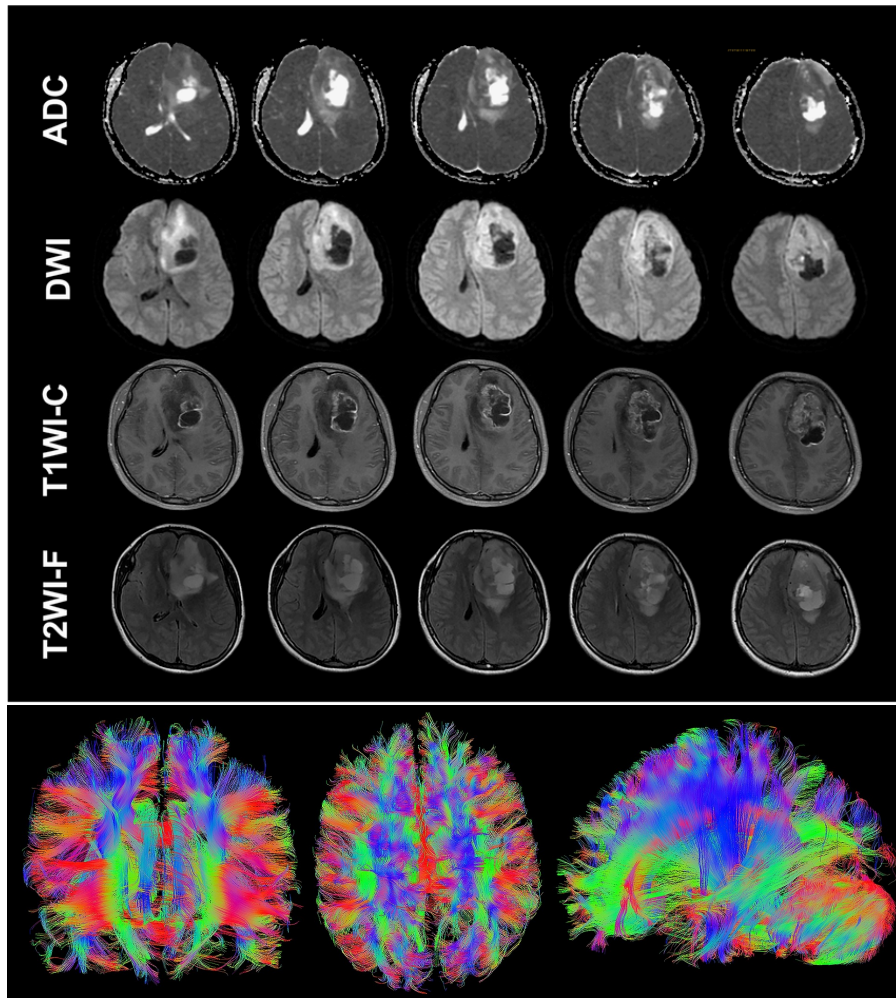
First figure: MRI images of the brain in patients with grade IV glioma, including apparent diffusion coefficient (ADC), diffusion-weighted imaging (DWI), T1-weighted contrast-enhanced, and T2-weighted FLAIR images, revealed tumour presence and significant surrounding brain edema. (Source [506]; used under the terms and permission of License CC BY 4.0, see <https://creativecommons.org/licenses/by/4.0/>)
